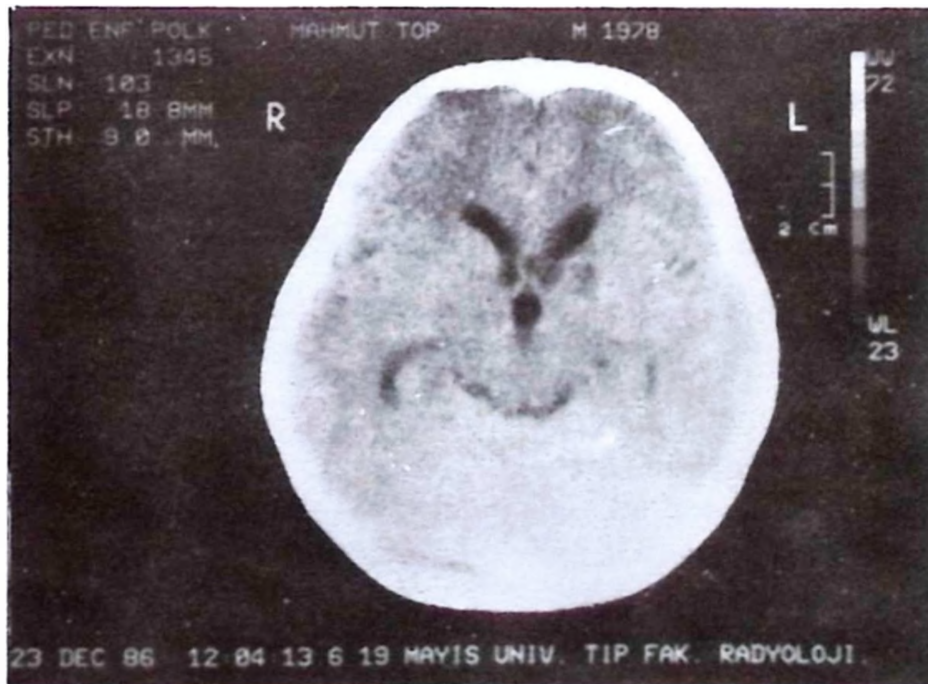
Precontrast CT study of Case No. 8 shows a hypodense area (infarction) in the anterior part of the capsula interna on the left side.
